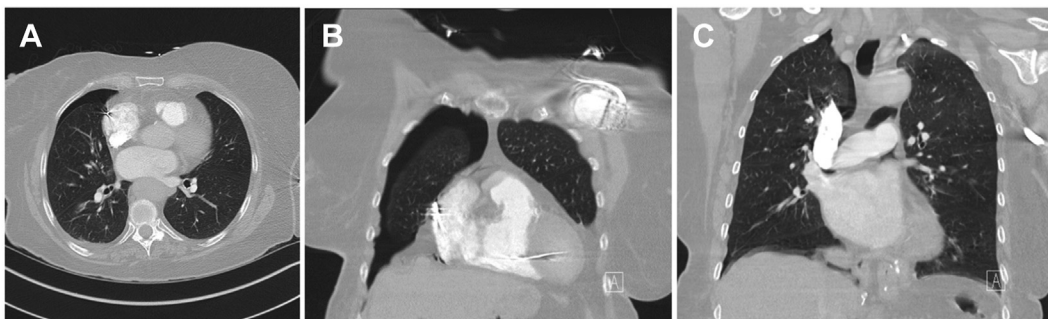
A: Axial chest computed tomography (CT) demonstrating contralateral pneumothorax. B: Coronal chest CT demonstrating lead tracking into contralateral pleural space C: Pneumomediastinum resulting from right atrial lead perforation
